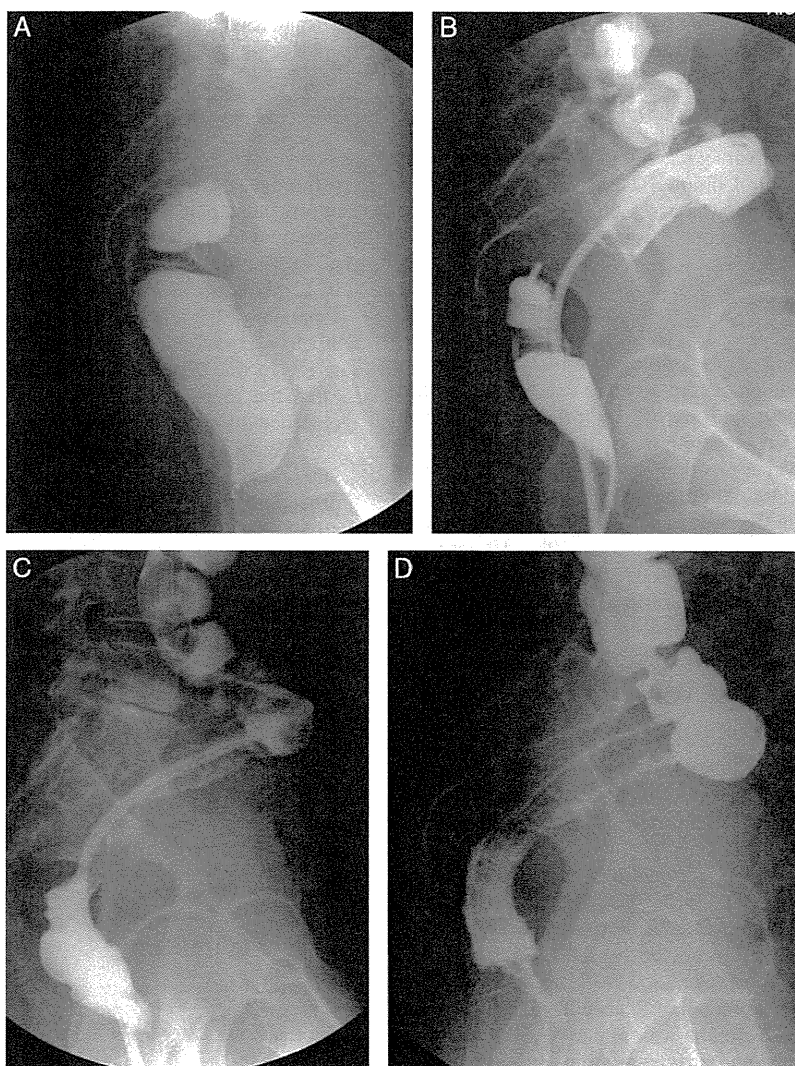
A 47-year-old woman who underwent rectal stenting for Schnitzler metastasis using an uncovered Ultraflex stent (length, 15 cm; diameter, 18 mm). A, Contrast enema using a water-soluble contrast medium showed that the rectum was completely obstructed. B, A catheter was passed through the obstructed portion and contrast medium was injected. C, A guide wire was inserted through the anus far enough to pass through the obstructed portion. A stent delivery catheter was placed over the guide wire under x-ray fluoroscopy. D, The stent was appropriately placed on the obstructed portion.
